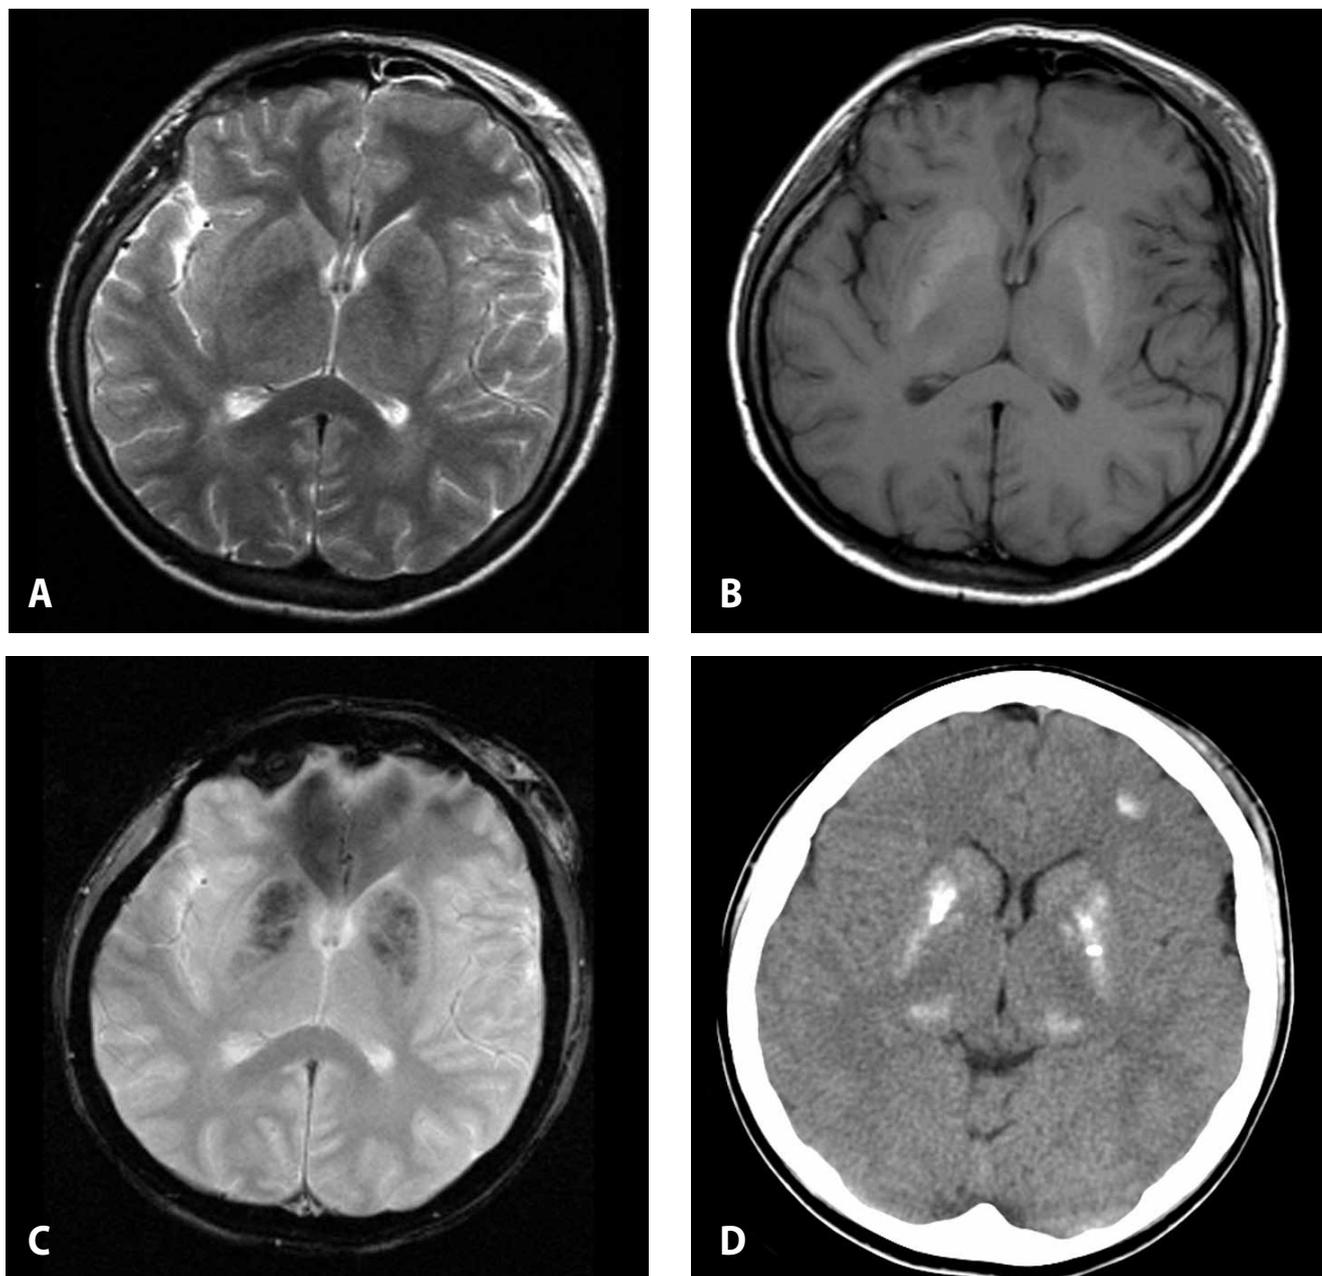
Normal appearing brain parenchyma on T2W axial image in a 24-year-old patient with pseudohypoparathyroidism (A) associated with hyperintense signal in the basal ganglia on T1W sequence (B) and hypointense on GRE T2W sequence (C) while calcium depositions in basal ganglia, left subcortical region and thalami on corresponding CT image are evident (D). Note that thalamic calcifications are noted only on CT while all three MR sequences are completely inconclusive.
